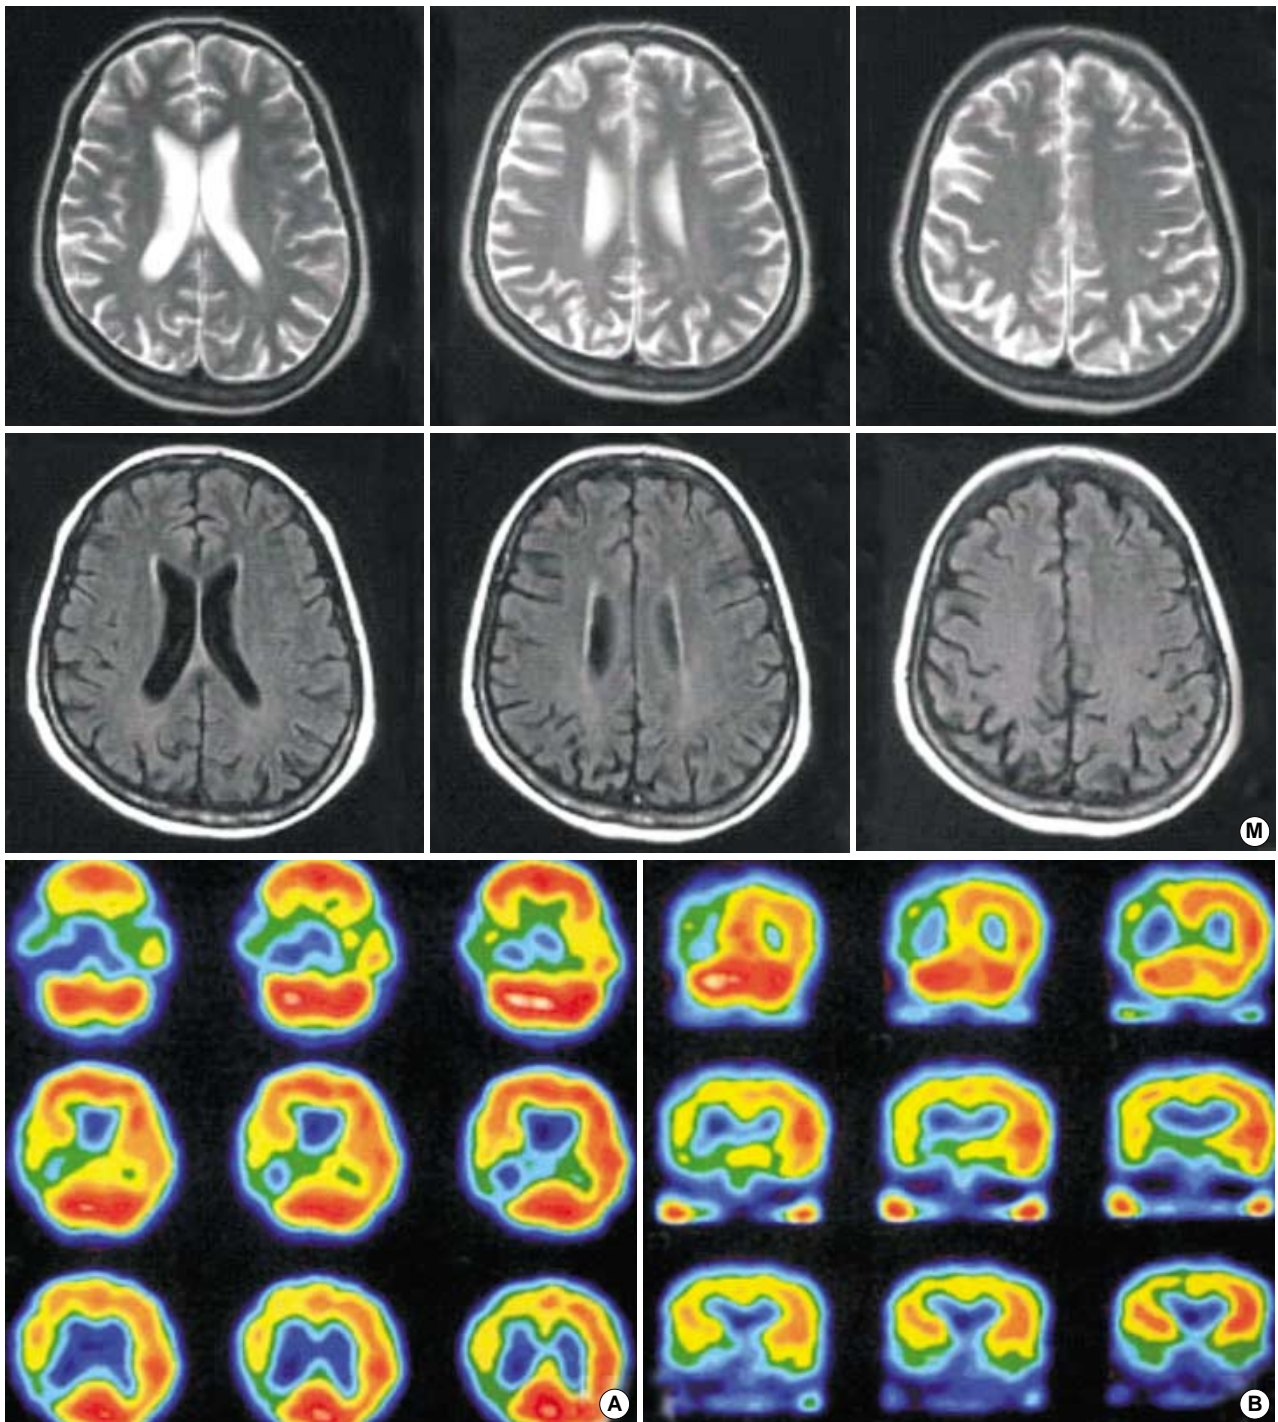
(M) MRI of the brain showed generalized mild brain atrophy with suspicious right posterior preponderance. No evidence of vascular or mass lesion is noted. Upper panel, T2-weighted axial images; Lower panel, FLAIR axial images (M). (A, B) 99m-Tc SPECT revealed profound perfusion defects in right temporal, and temporoparietal regions. A. axial; B. coronal view.
